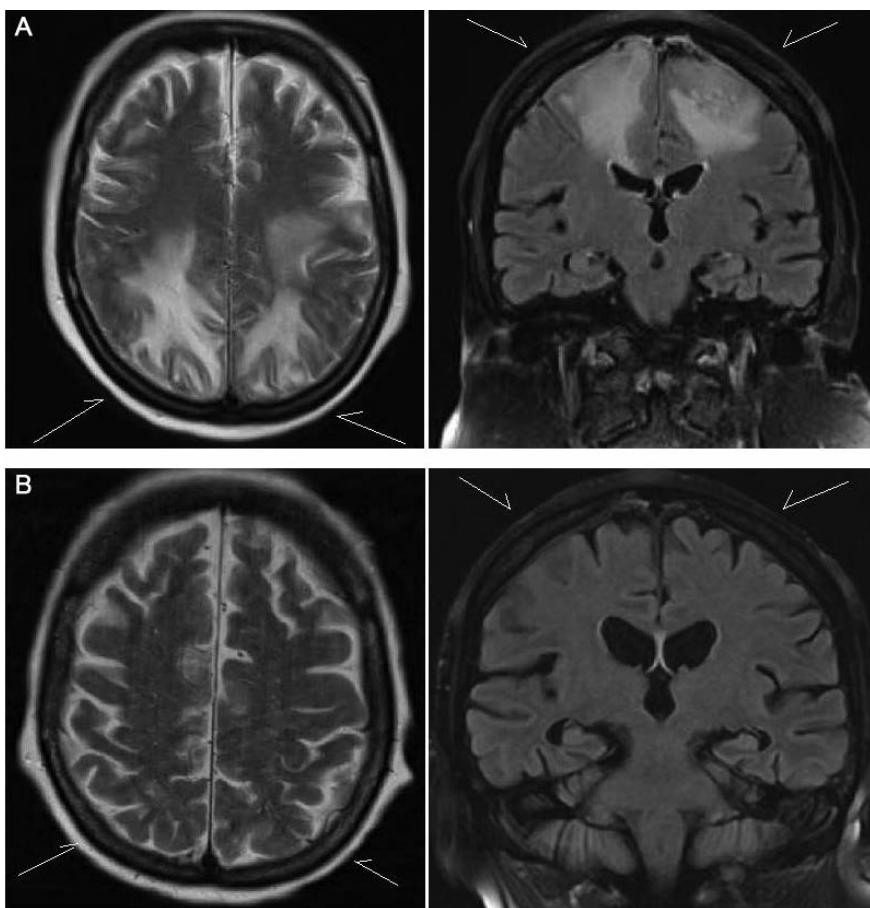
A) Magnetic resonance imaging (MRI) (transversal section, T2) and coronal section, shows the symmetrical biparieto-occipital edema in the white matter (arrows); B) Two weeks after the first MRI a repeated MRI shows complete resolution of the edema (arrows). No tumor can be seen.
